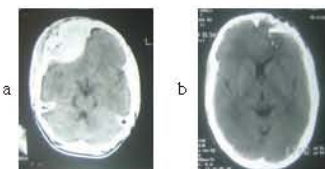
CT scan showing a) depressed skull fracture with EDH on Rt. Frontal region b) depressed fracture over Lt frontal region.
